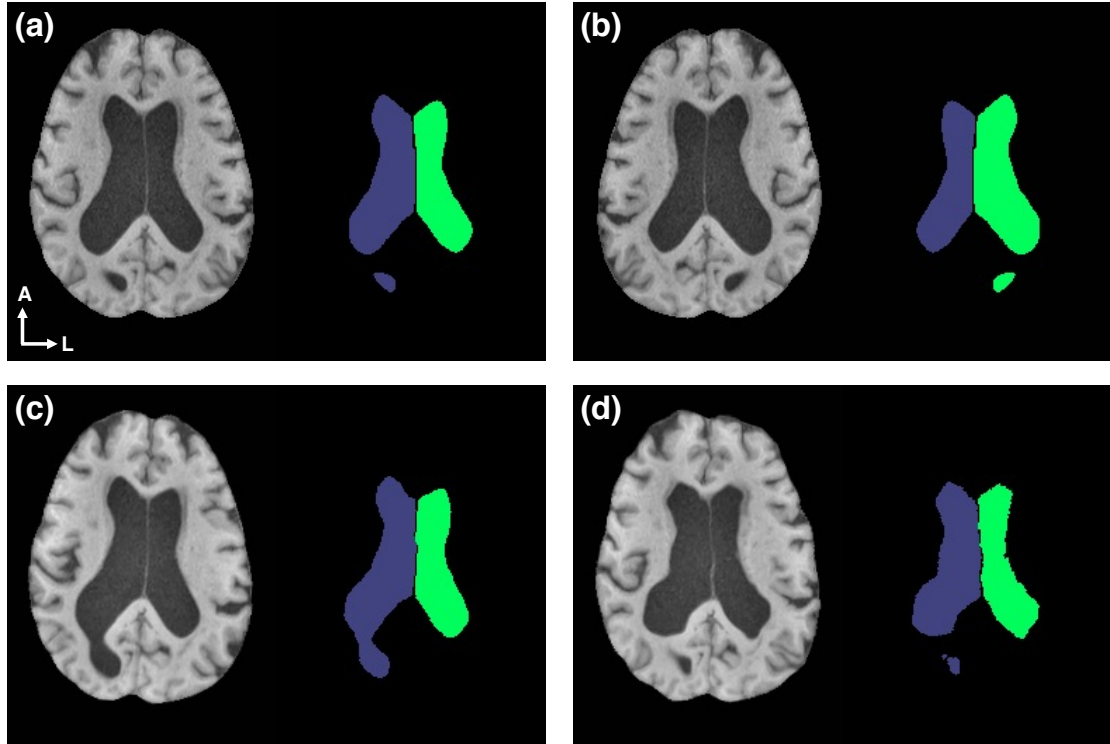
Data augmentation examples (MRI and the corresponding label image). (a) The original image; (b) Left-right flipping; (c) Random rotation; (d) Elastic deformation. A = anterior; L = left.
